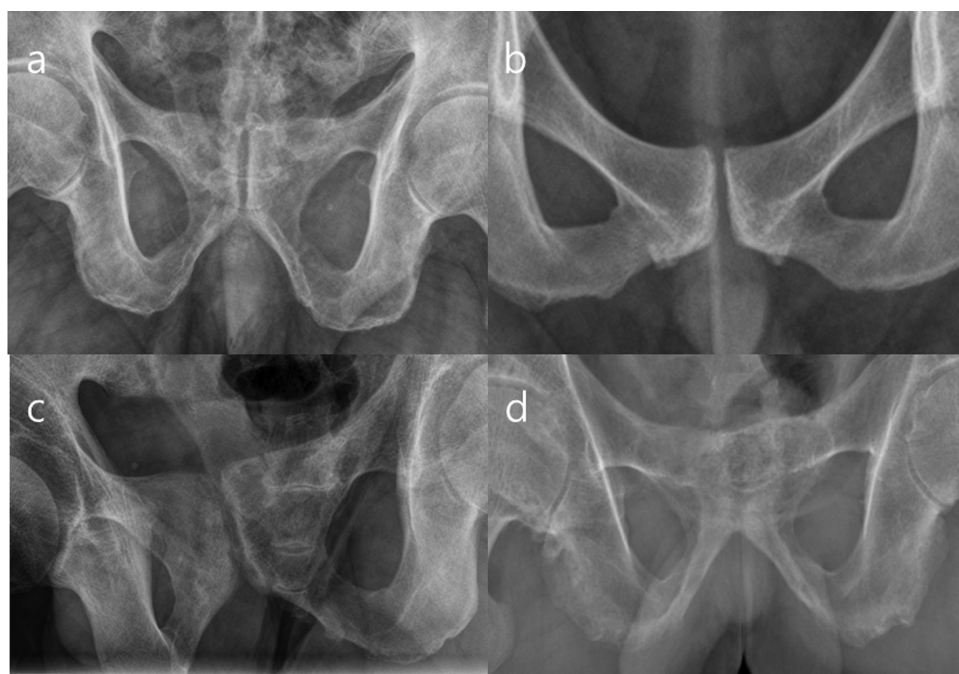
Radiographic changes in the symphysis pubis joint in patients with ankylosing spondylitis include (A) irregularity, (B) subchondral sclerosis, (C) erosion, and (D) total ankylosis.
